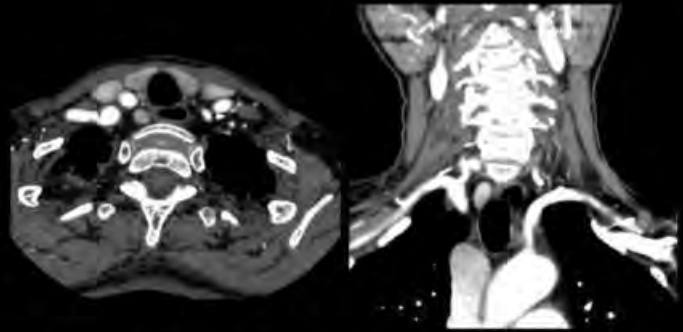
Axial and coronal CT images demonstrating an enhancing right para-esophageal parathyroid adenoma.
